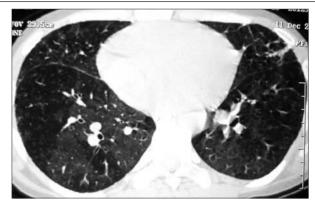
High-resolution computed tomography showing bilateral mosaic attenuation.
